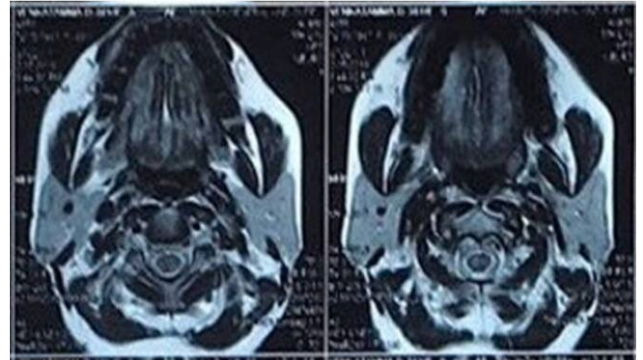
MRI of tongue reveals that the lesion appears to be involving left superior longitudinal and left styloglossus muscle
